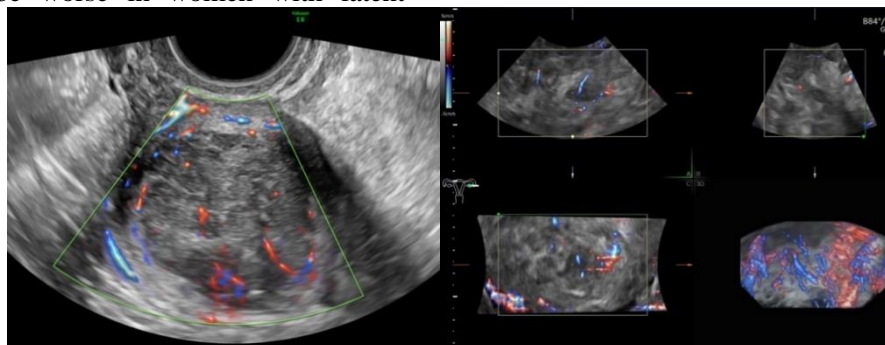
Typical ultrasound images of uterine leiomyosarcoma seen on 2D (A) and 3D (B) sonoangiography. Chaotic and central vessel arrangement within the mass can be better seen at three-dimensional blood flow imaging
